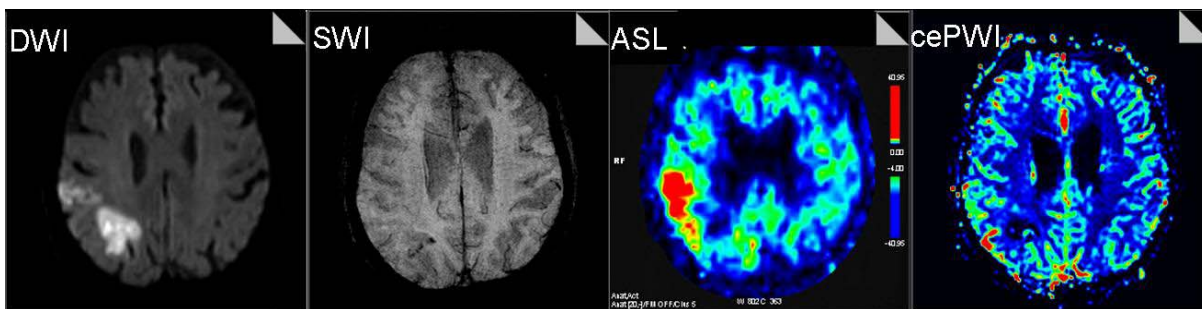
Example of Ischemic lesions 5 days after stroke, hypoperfusion is found around lesion 1 (strong hypersignal on DWI, b=1000) on both cePWI and ASL, with localized microhemorrhage in SWI; lesion2 (moderate hypersignal in DWI) correspond to hyperperfusion in ASL non evidenced by cePWI, SWI evidenced loss of GM/WM contrast in corresponding area. No bbb leakage was evidenced on T1 post gadolinium.
